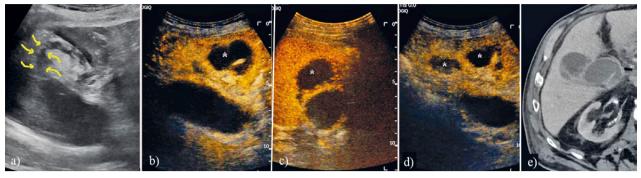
Acute cholecystitis, gallbladder perforation: a) grayscale (arrows indicate perforation); b), c) and d) CEUS exploration (asterisk indicates liver abcesses); e) CT exploration (transversal).
